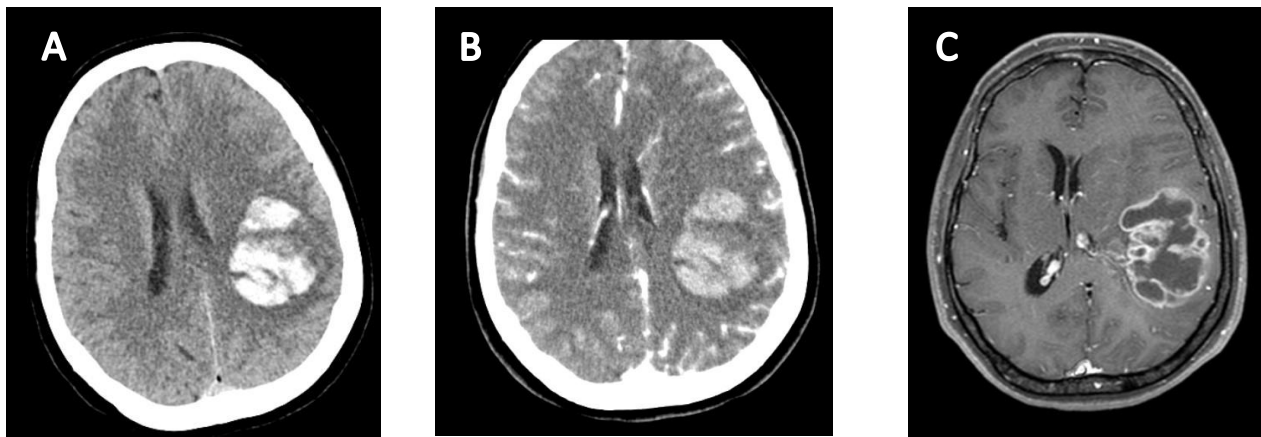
(Case No. 3): A. Non enhanced CT scan showing ICH at first symptoms; B. Contrast enhanced CT scan with no obvious tumour; C. Contrast enhanced MRI 3 months later showing tumor, highly suggestive for GBM.
